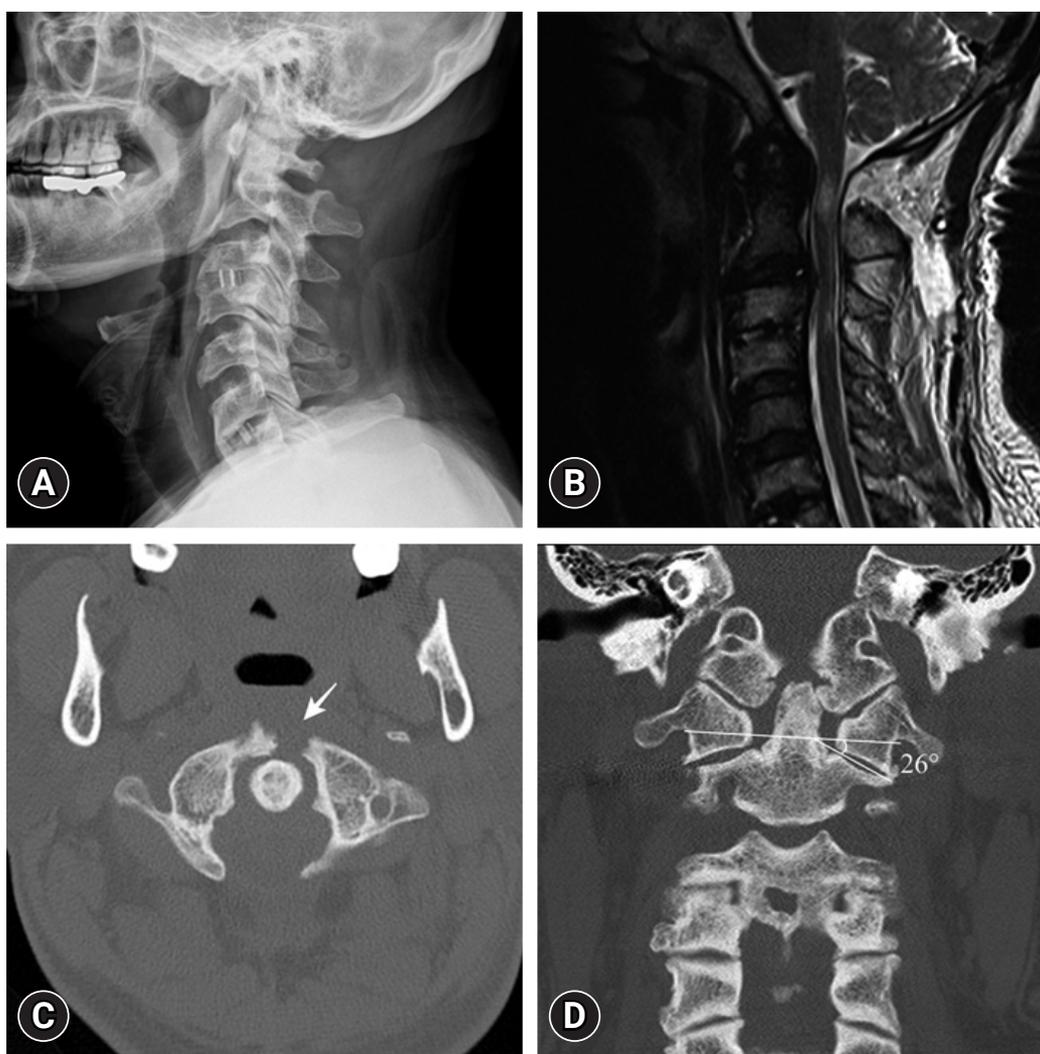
(A) Lateral cervical radiograph following C1 laminectomy without fusion (CLWF). (B) Postoperative T2-weighted magnetic resonance imaging showing the removed posterior C1 arch and resultant decompressed spinal cord. (C) Computed tomography (CT) scans obtained 8 months after CLWF showing fracture of the anterior arch (white arrow). (D) Coronal view of the CT scan demonstrating a large inferior facet angle of 26°.
